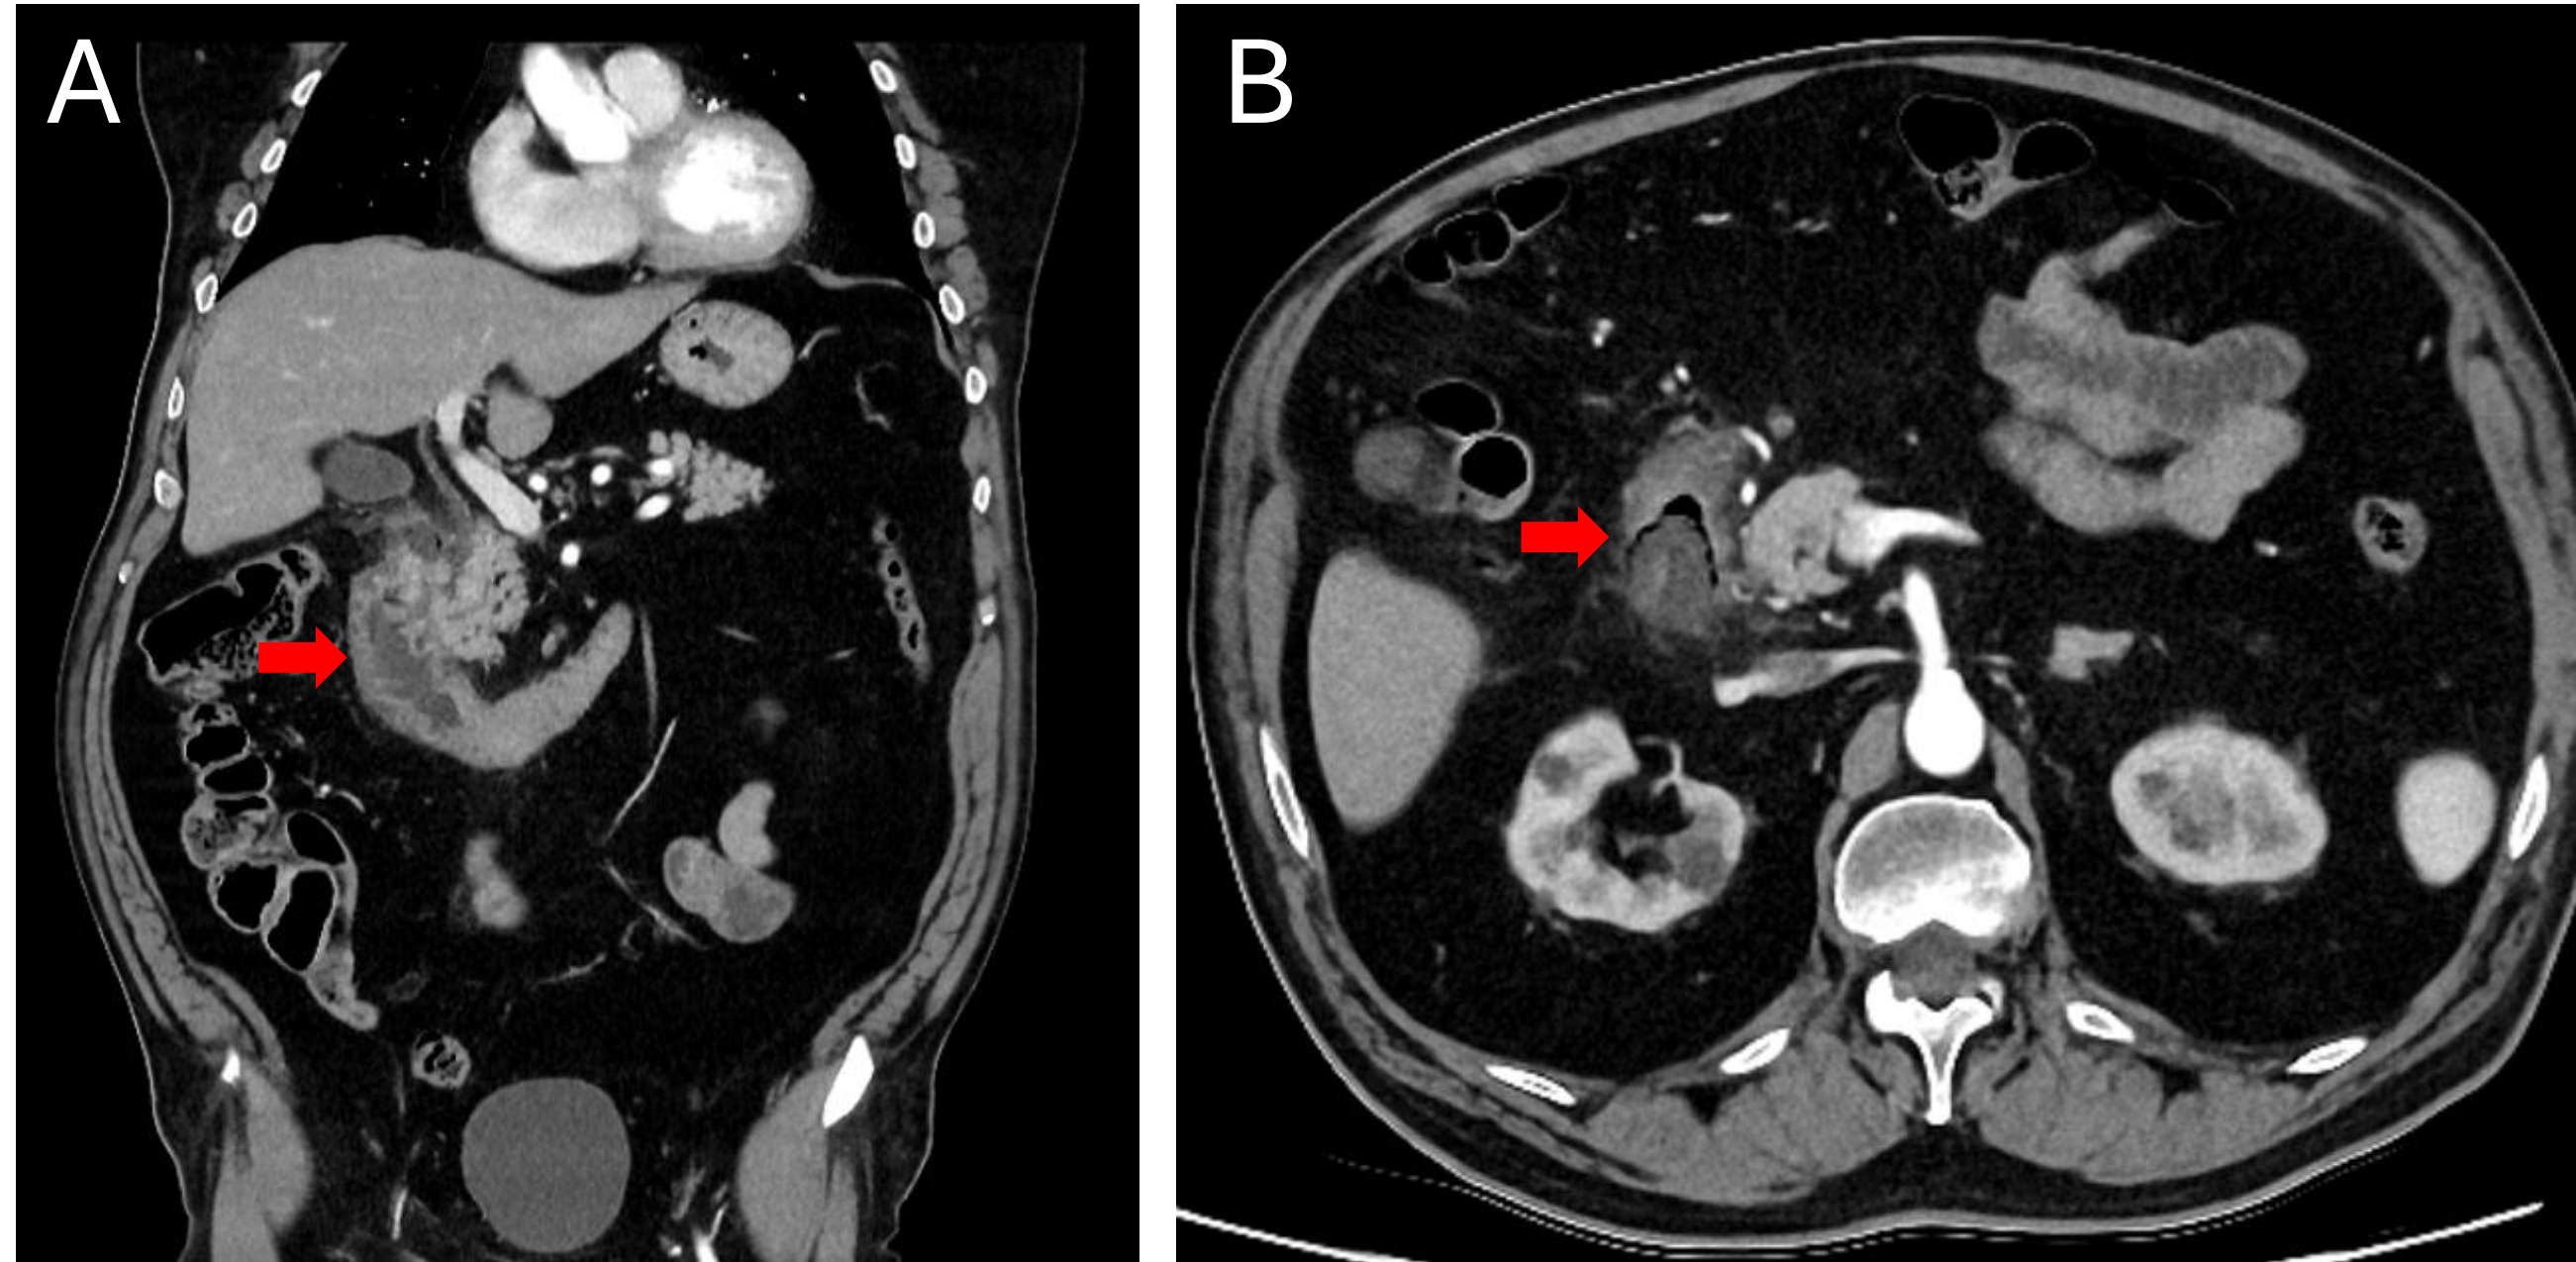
CT Imaging on Admission showing Duodenal Pathology.
